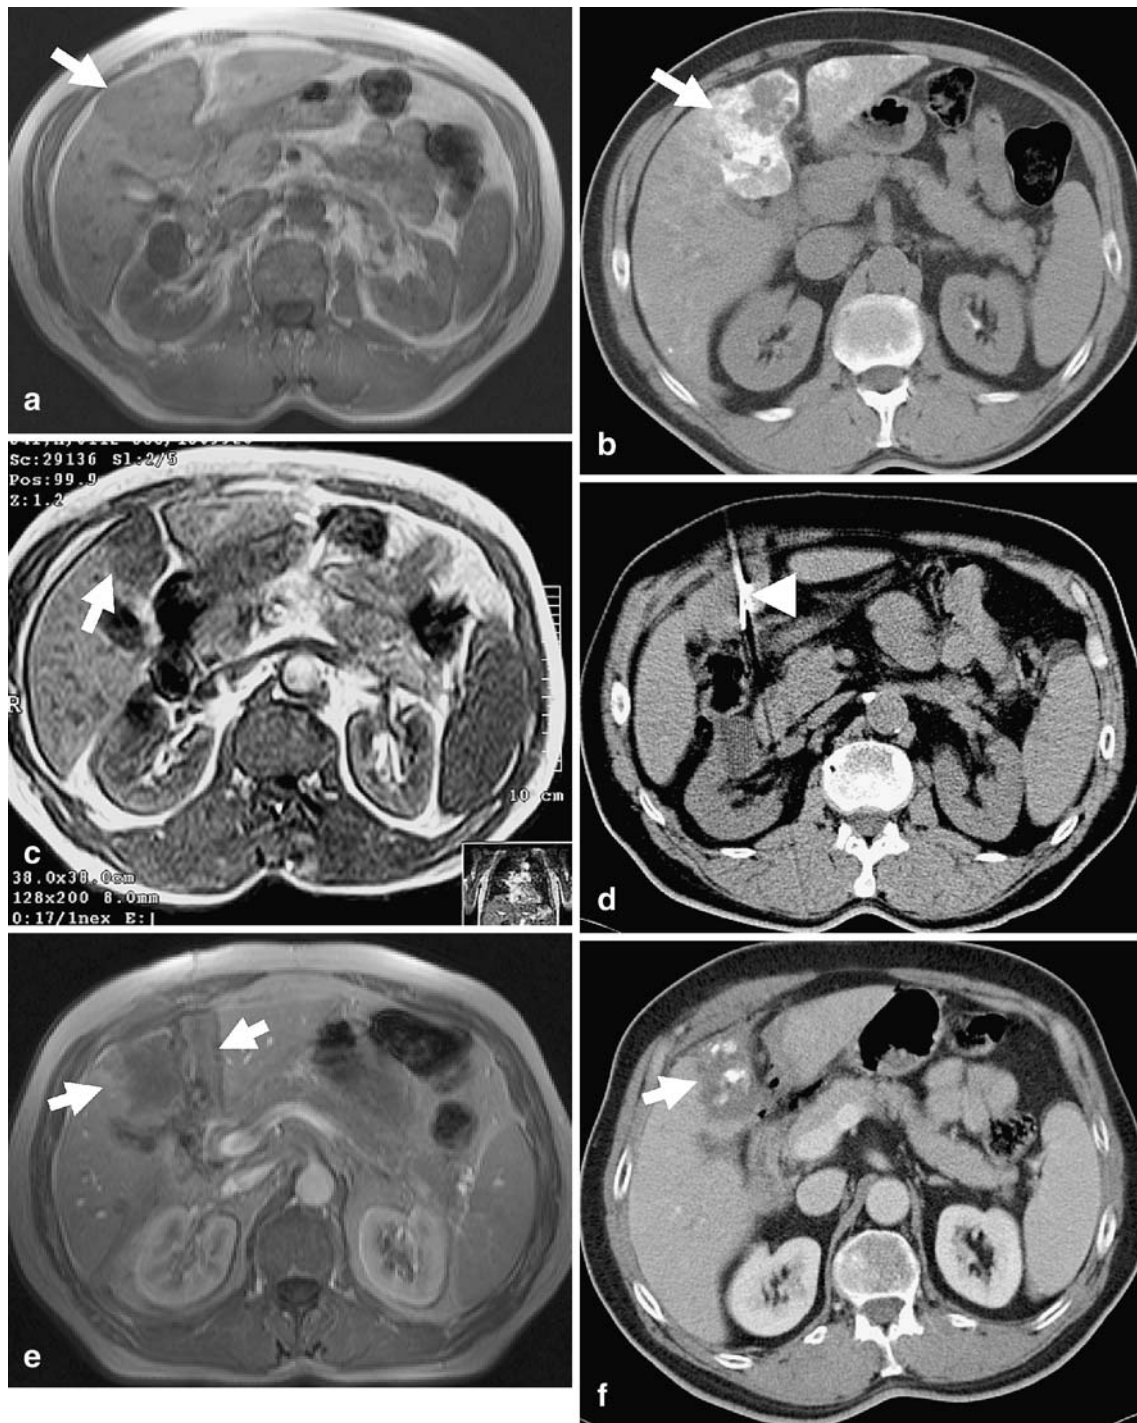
A 64-year-old patient with a large HCC nodule in segment 4 and three further lesions. (a). Documentation of the largest lesion (*arrow*) in transverse GRE T1-weighted (TR/TE=140/12; flip angle 80°) MR images. (b) Unenhanced transverse CT scan after the second course of chemoembolization also documented high lipiodol retention (*arrow*) in the treated tumor and a beginning of tumor decrease. (c) After the third course of TACE, a 60% decrease of the tumor (*arrow*) could be observed on unenhanced transverse GRE
